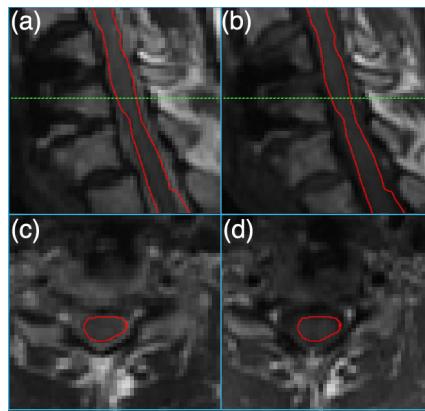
Sagittal (a) T₂-weighted and (b) T₁-weighted 3D-MSI MRI images of an instrumented damaged spinal cord. Axial sections, reformatted at the level of the dashed green line from (a) and (b), are shown in (c) and (d) respectively. The spinal cord is outlined in red in all images.
